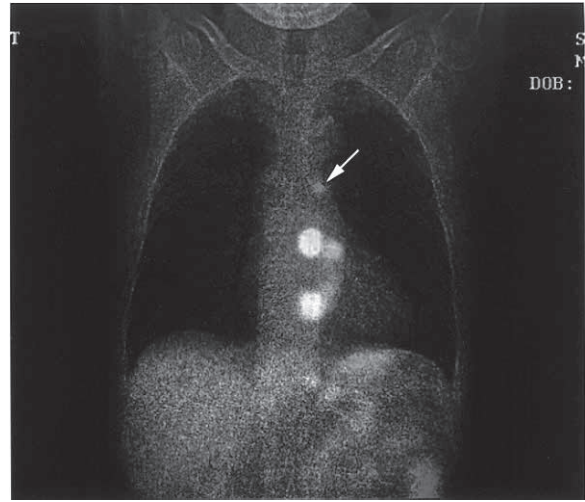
Fusion image of lymphoscintigraphy obtained from left anterior oblique projection and scout view for CT. Since the lymphoscintigram obtained from anterior projection failed to visualize SLN, we fused lymphoscintigram obtained from anterior lateral projection and a scout view of CT. There was no gap in vertical sides between those two images. The accumulation is suspected to be in the left recurrent nerve lymph node station (*arrow*).
